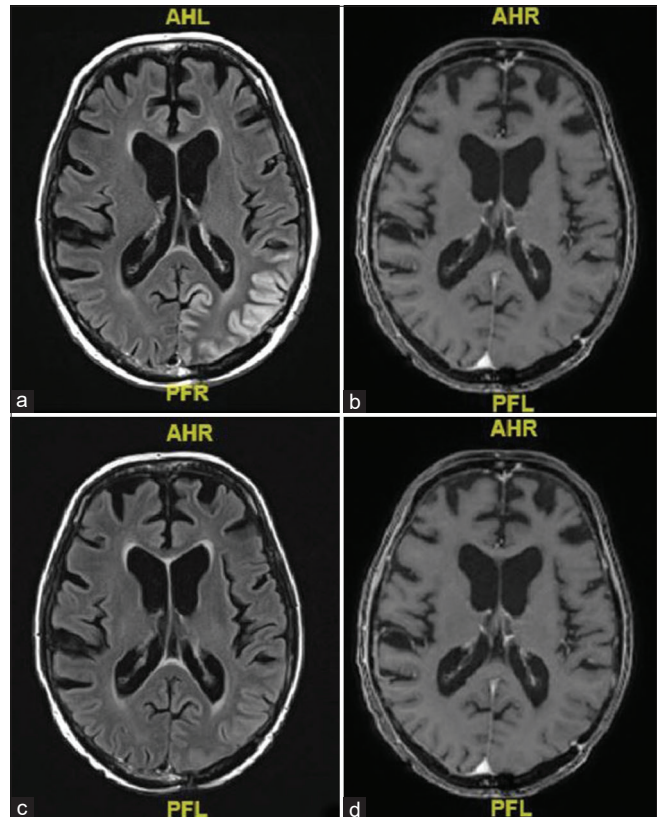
Brain MRI at presentation and after 10 days of SMART syndrome. Gyral enhancement of the left parietooccipital region with mild swelling on axial postcontrast FLAIR MRI (a) and on postcontrast T1-weighted imaging (b). Complete resolution of findings 10 days later on postcontrast FLAIR (c) and postcontrast T1-weighted imaging (d).
